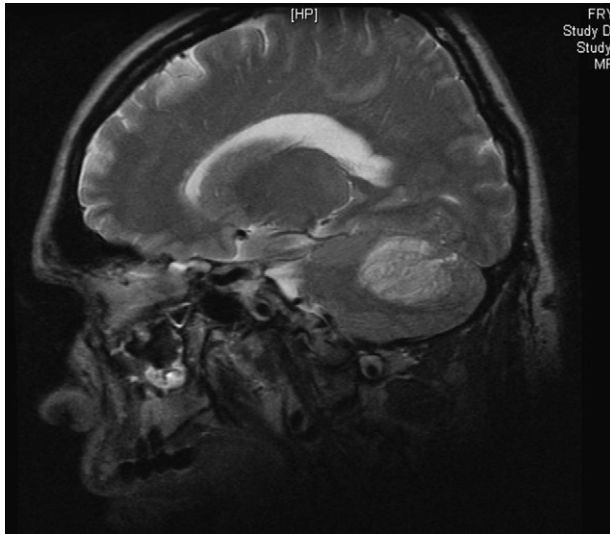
T2-weighted sagittal MR image scan of the neurocranium demonstrating a nonenhancing hyperintense mass in the left posterior fossa corresponding to the known picture of Lhermitte–Duclos disease without signs of hydrocephalus.
